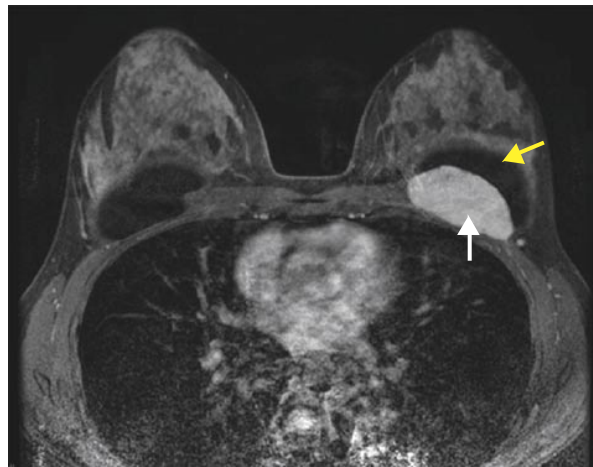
Magnetic resonance imaging (T1 axial image with contrast) showing prosthesis (yellow arrow) and chest wall involvement with fibromatosis (white arrow).
